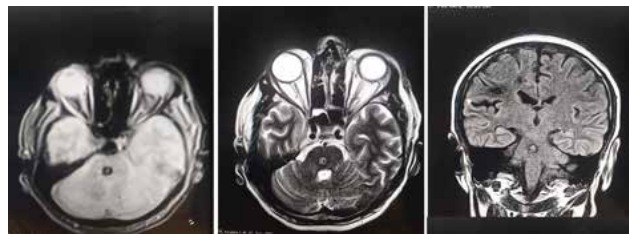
MRI T1 weighted images showing lesions in pons and cerebral hemispheres.
